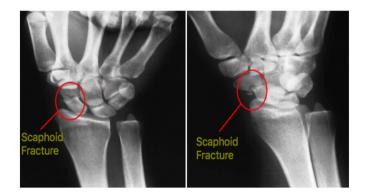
Radiographs of an acute displaced scaphoid wrist fracture prior to surgery, adapted from [26].
